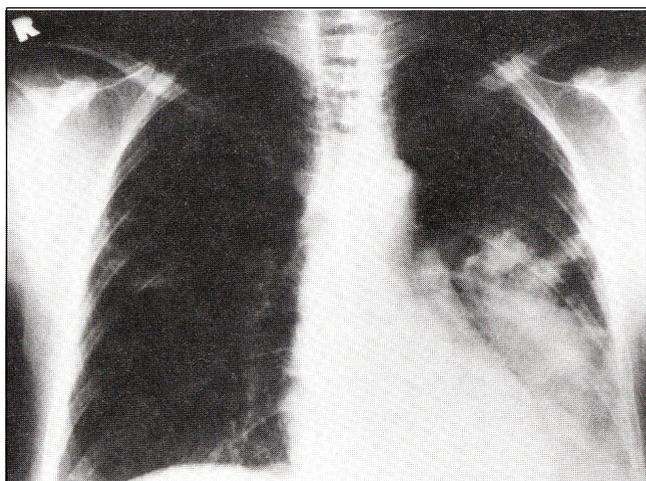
Chest radiograph of case 1 at admission. Note the extensive left lower lobe opacity. There is a barely visible opacity on the right
